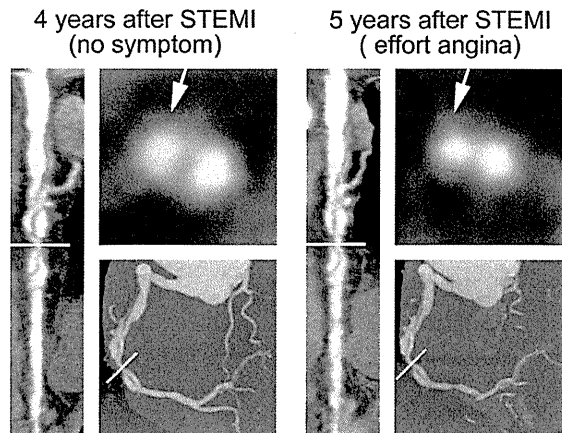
Coronary CT angiography successfully identified the lesion (lines) where the true lumen stenosis of dissected RCA had progressed for a year (arrows).
